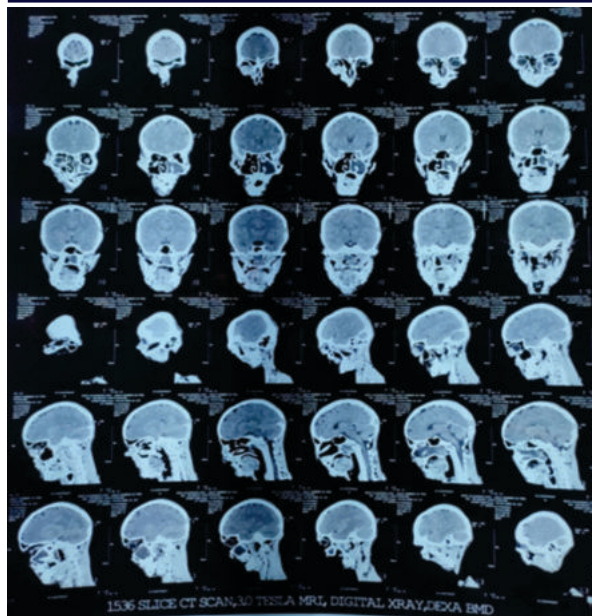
3D CT Scan of the face
